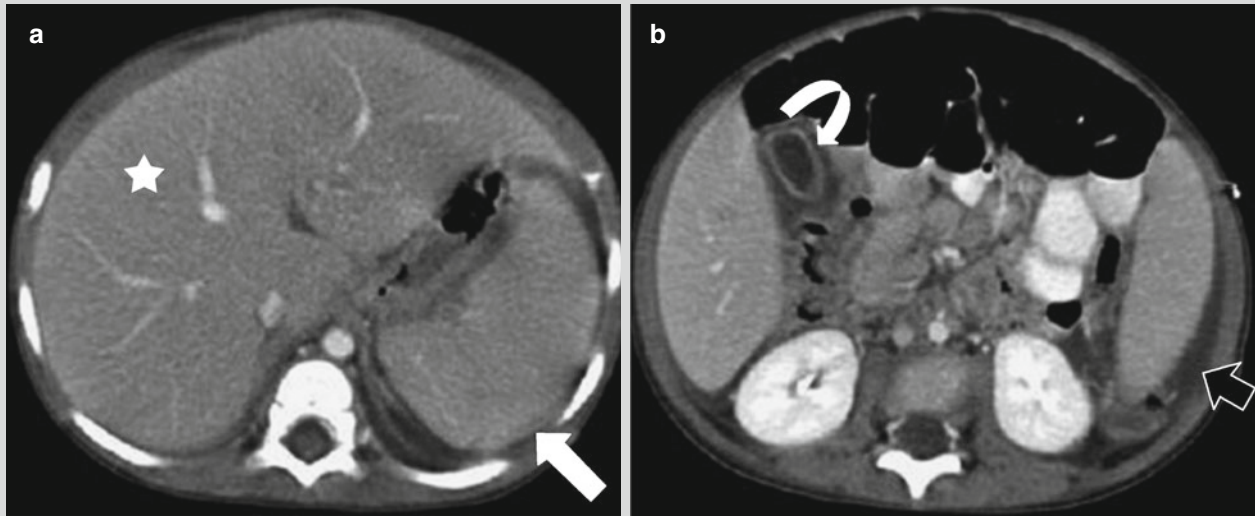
Abdominal organs (ileum, spleen, and cholecyst) and lesions of typhoid fever. (a, b) CT scanning demonstrates enlarged liver (star) and spleen (white arrow), thickening of the cholecyst wall (curving arrow), and ascites (black arrow)
